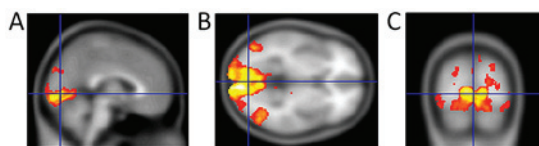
Functional magnetic resonance imaging in a patient with normotensive glaucoma (age, 61 years). V, 1,0 without correction. Cup-to-disc diameter ratio, 1 (25). Yellow areas indicate increased activity. (A) Sagittal section, (B) transverse section and (C) coronal section.
